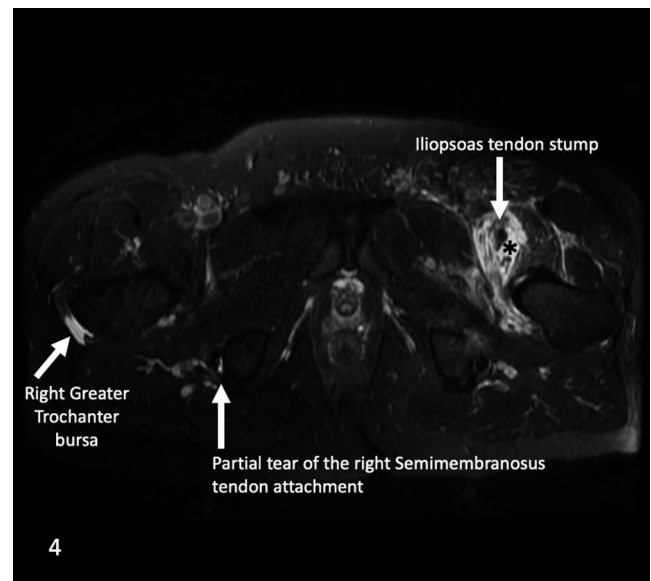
Axial T2 MR image of the pelvis with multiple findings, including right greater trochanter bursal distention, partial tear of the right semimembranosus tendon at its ischial attachment and the left iliopsoas tendon stump with surrounding edema (*) that tracks posteriorly toward the lesser trochanter
